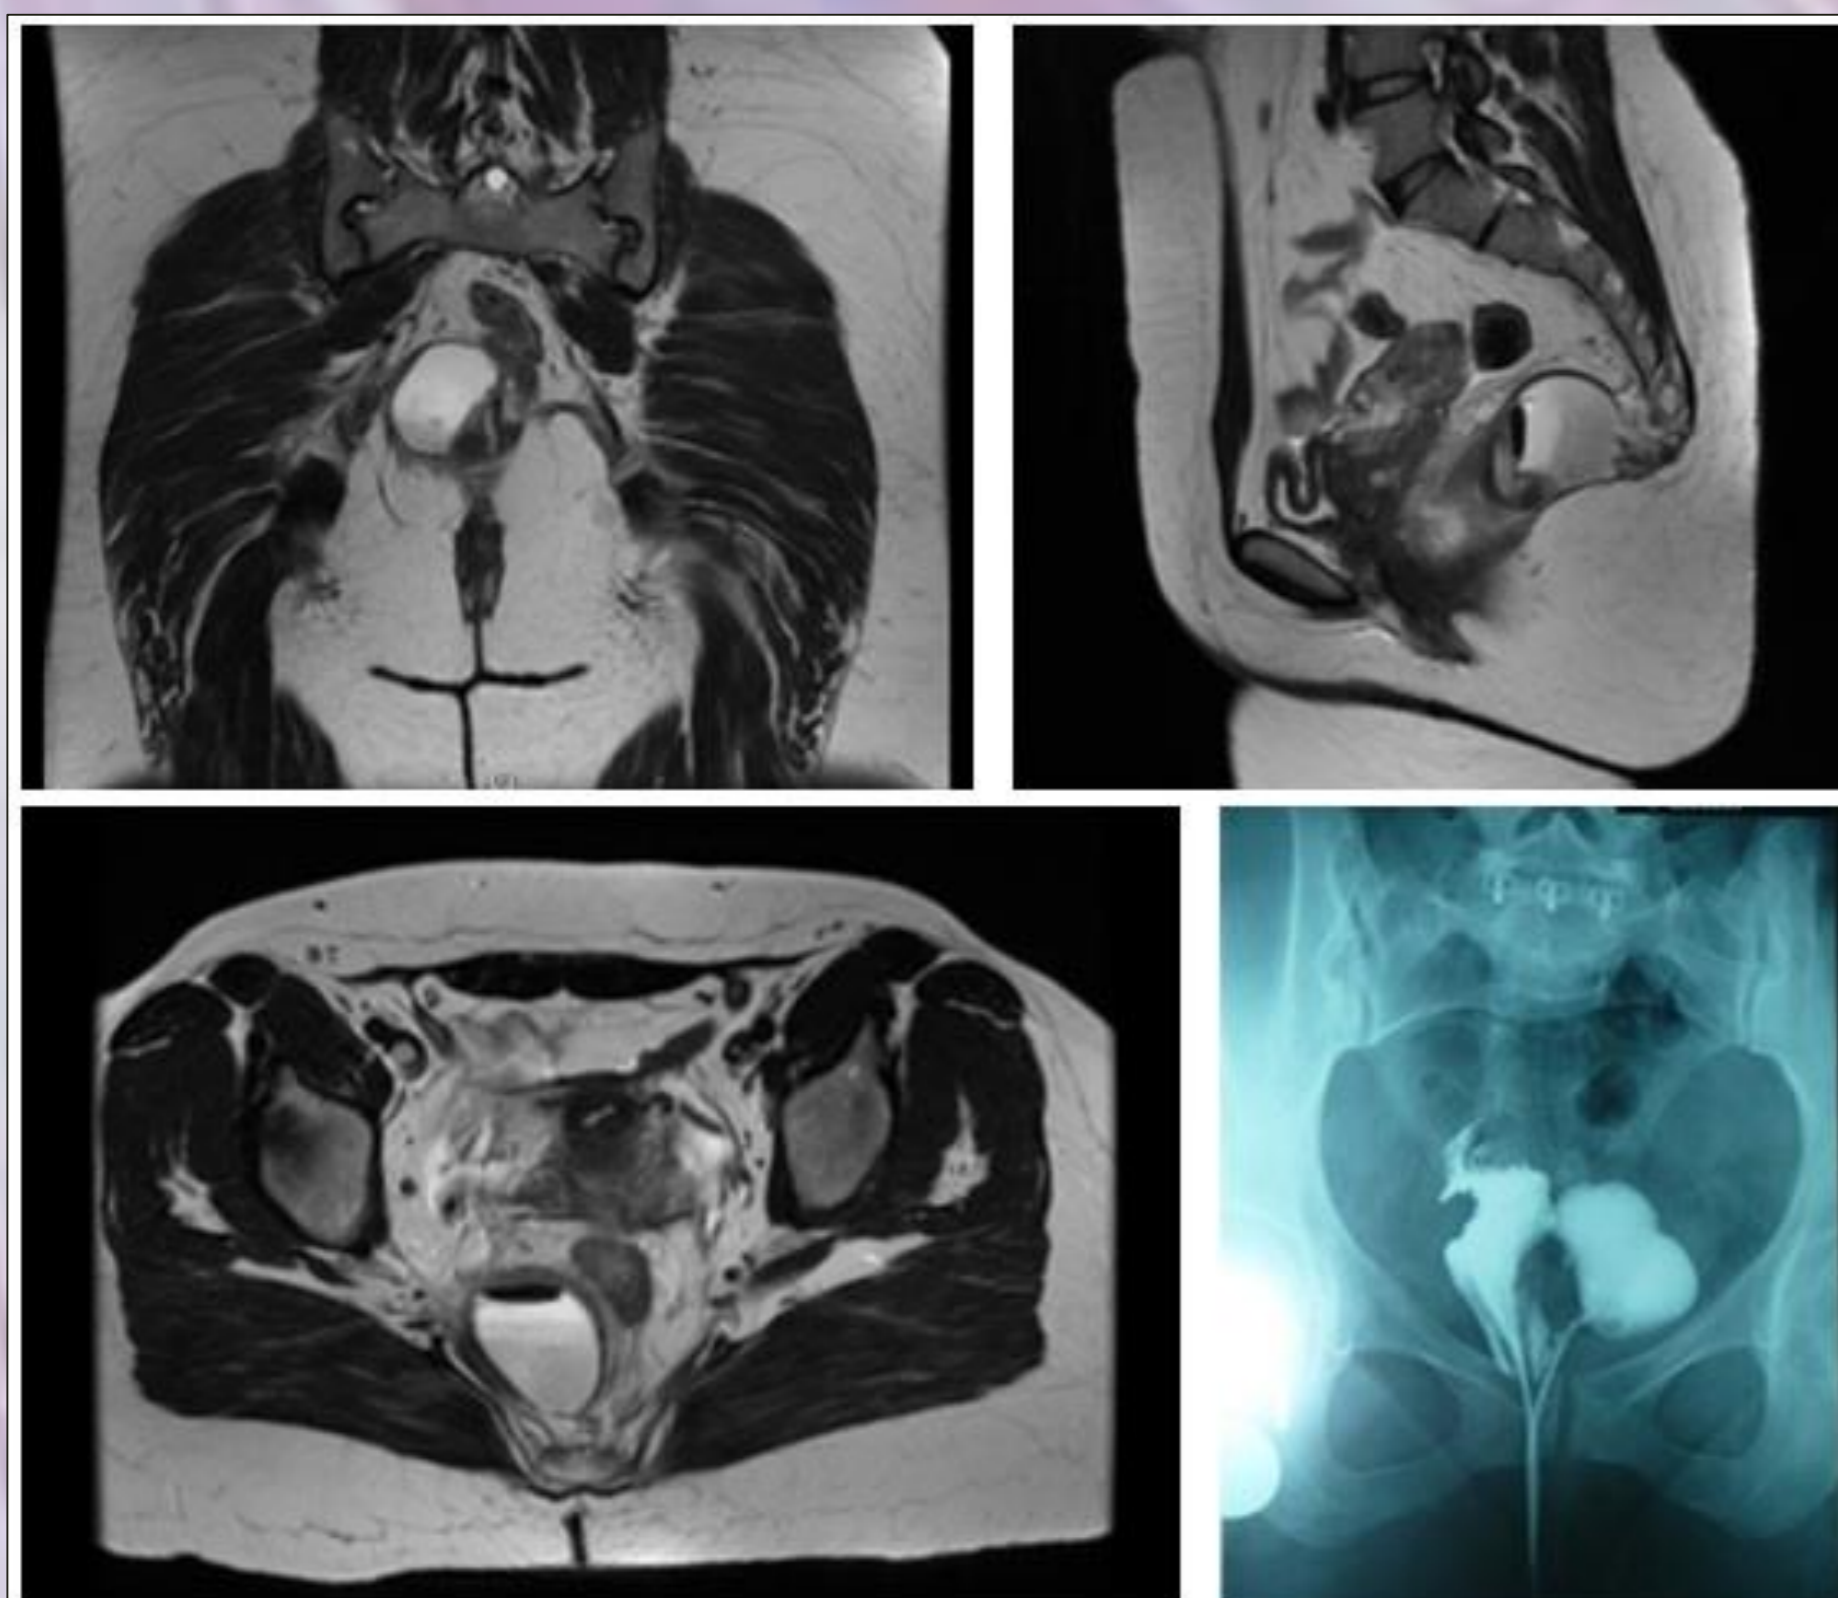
MRI and fistulography
